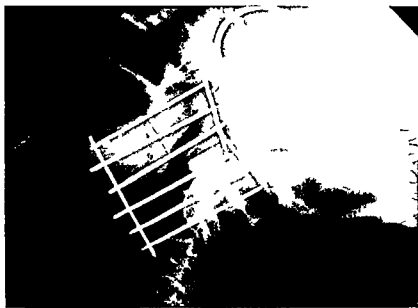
Radiographs of implant as performed. Anteroposterior and lateral views are required for the measurement of area. The ring is a magnification gauge.
